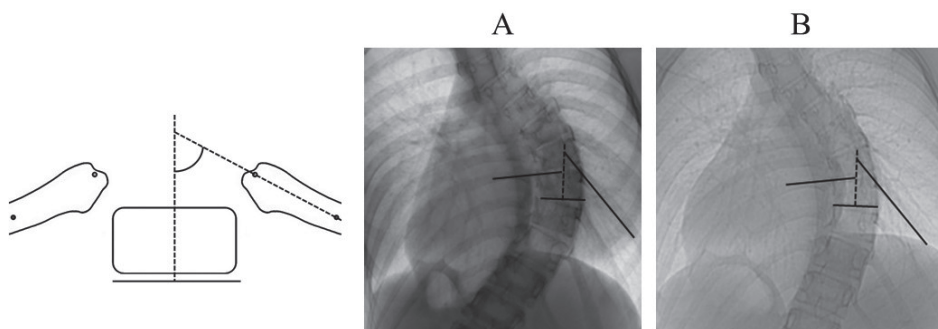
The 2D RVAD, according to Mehta, was measured on the conventional standing posterior-anterior radiograph (A) and digitally reconstructed radiograph (DRR) of the prone CT scan (B).⁴¹ The RVAD was the difference between the convex and concave rib vertebra angle. Mehta defined the rib vertebra angle as the angle between the rib line, a line through the rib head and rib neck, and a line perpendicular to the lower endplate of the vertebral body.⁴¹
